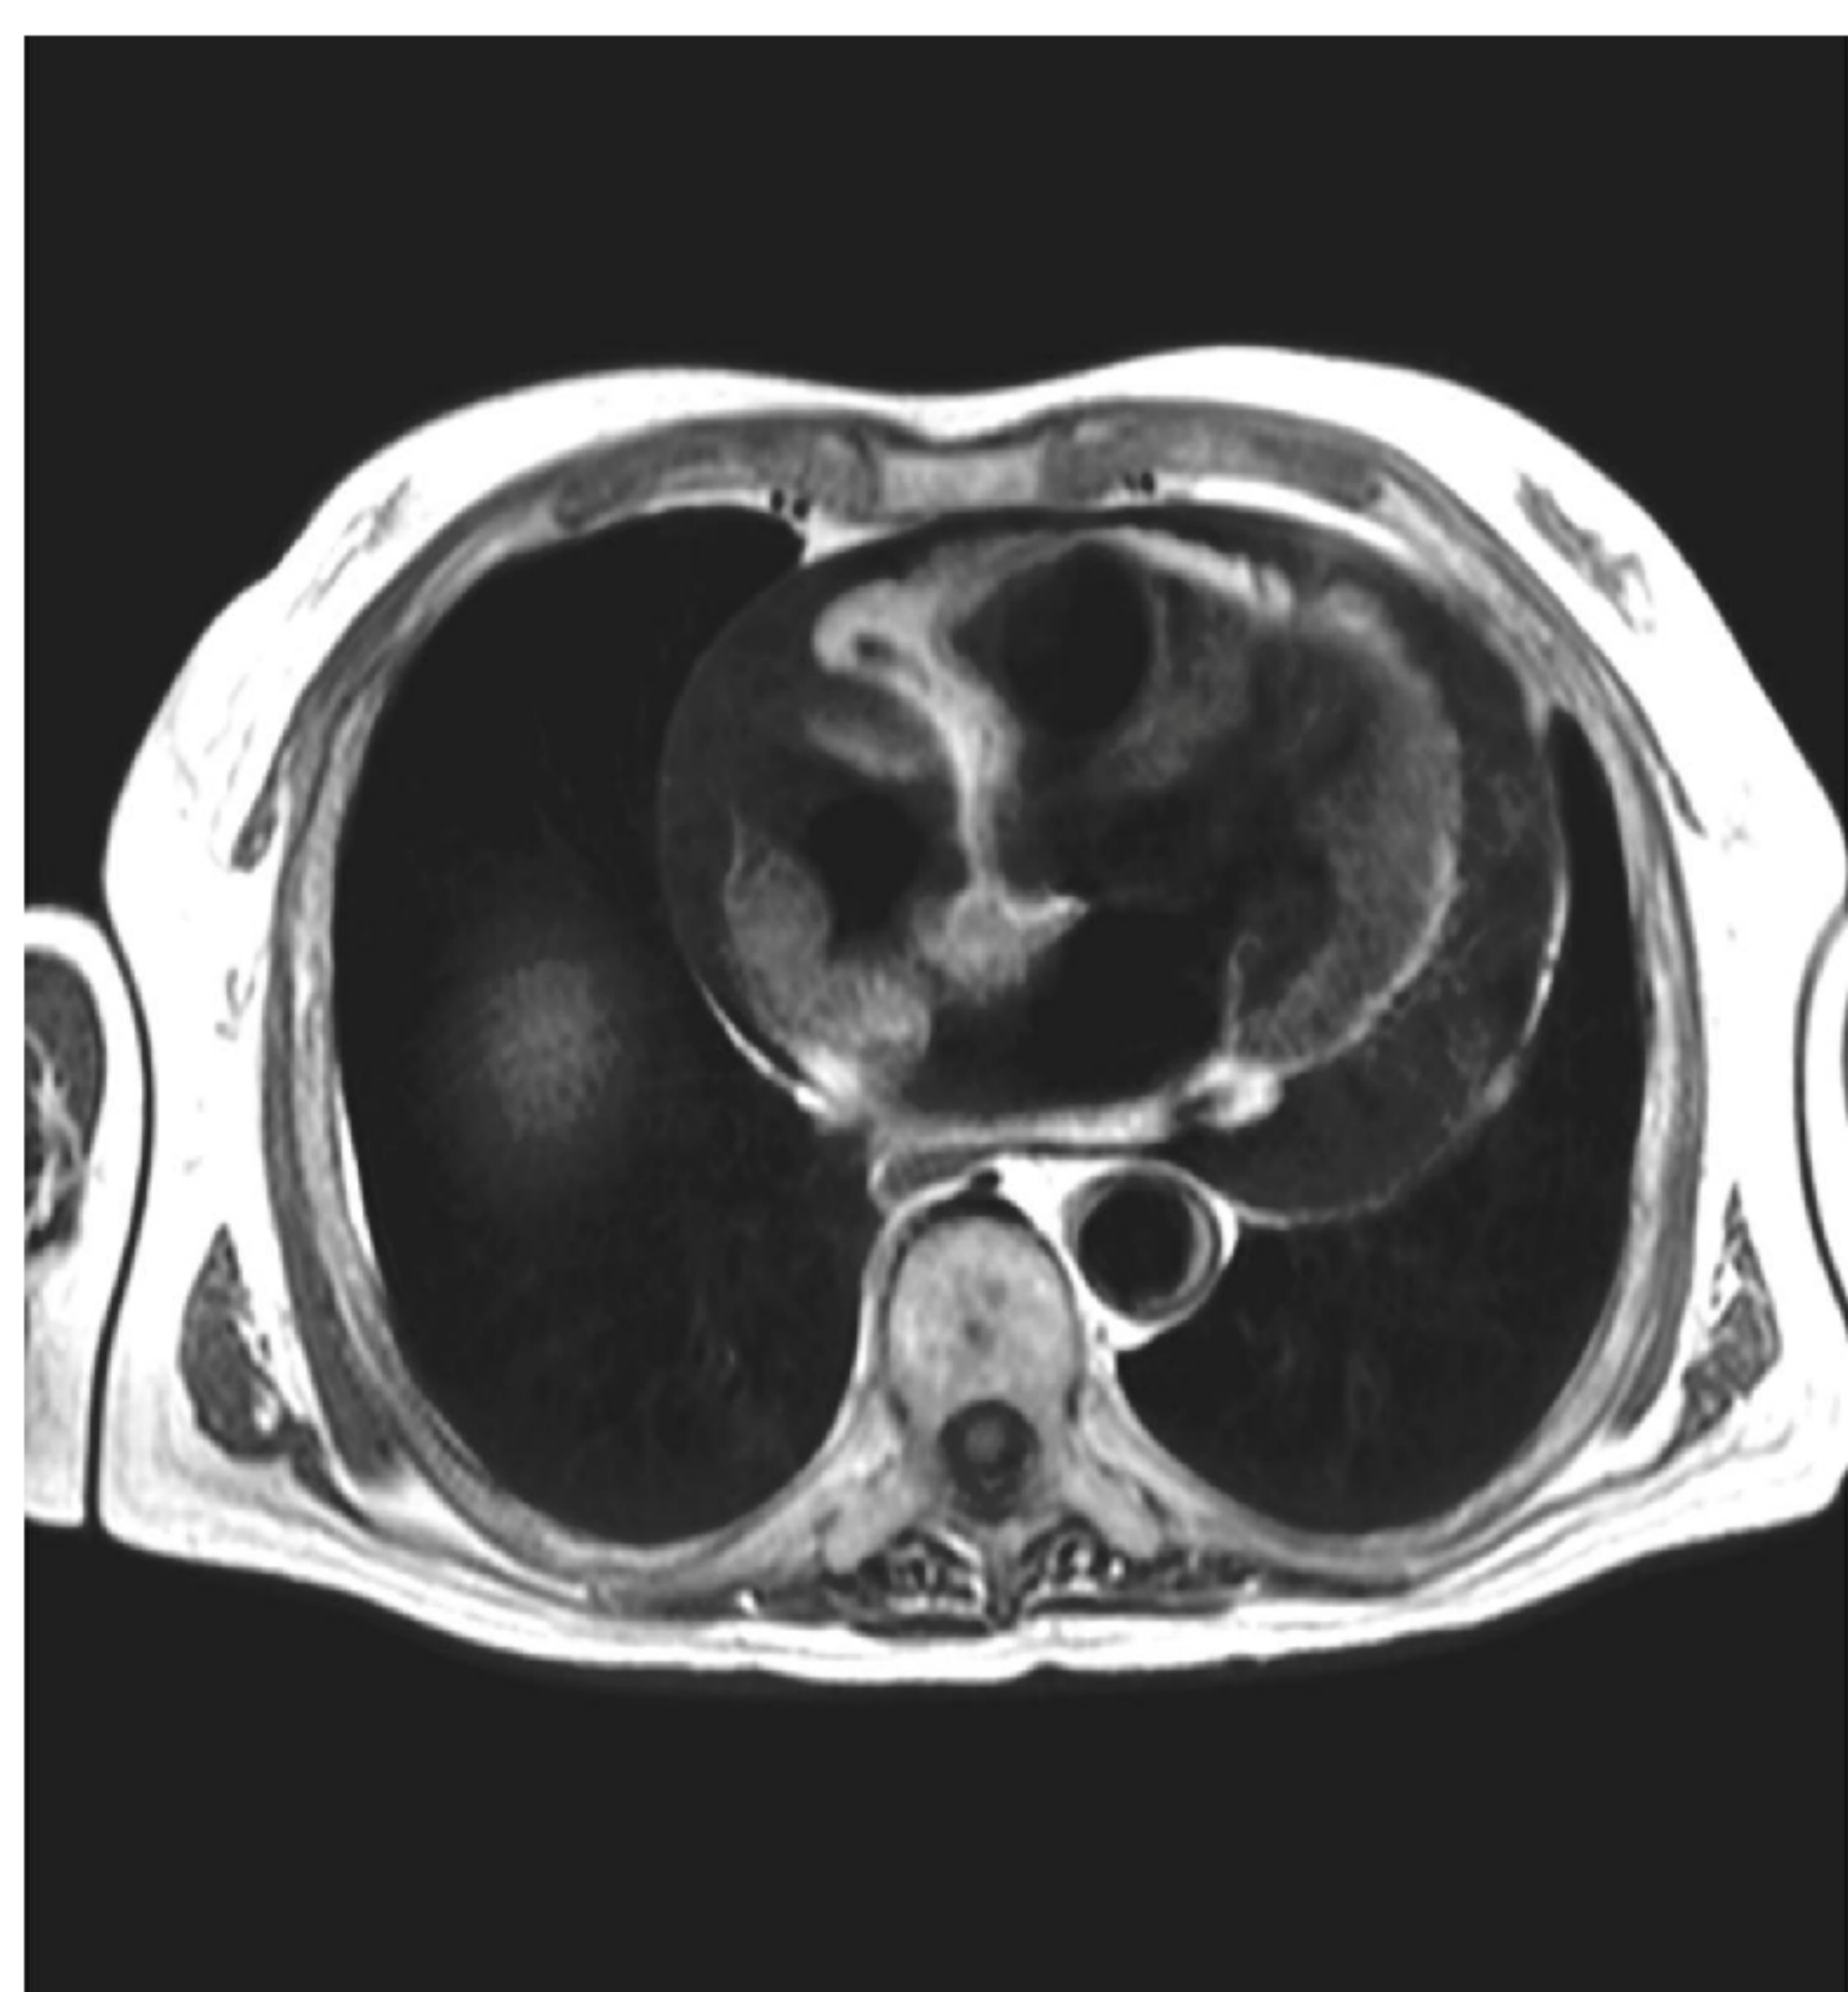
Cardiac MRI showing pericardial effusion and a mass infiltrating the interatrial septum
